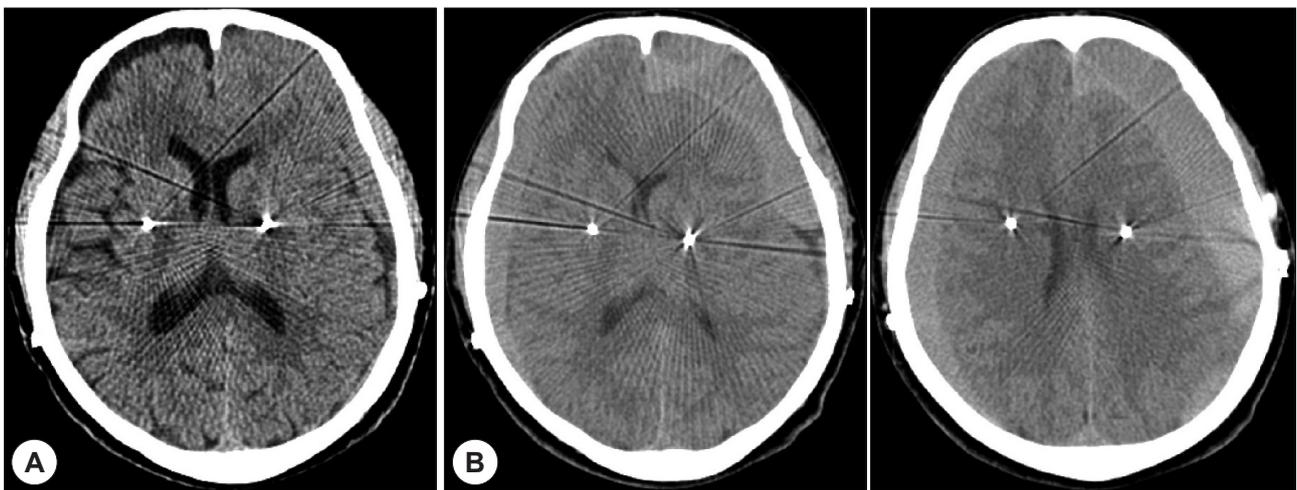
A : Follow-up CT scan after 1 month from the operation shows newly developed subacute to chronic subdural hematoma, left cerebral convexity, without significant mass effect. B : Follow up CT scan after 2 month from the operation shows newly developed chronic subdural hematoma right cerebral convexity and increased amount of subdural hematoma, left cerebral convexity with heterogeneous density. Also CT scan reveals increasing mass effect of hematoma and midline shift to right. The electrode is medially shifted due to ventromedial brain displacement associated with chronic subdural hematoma.
